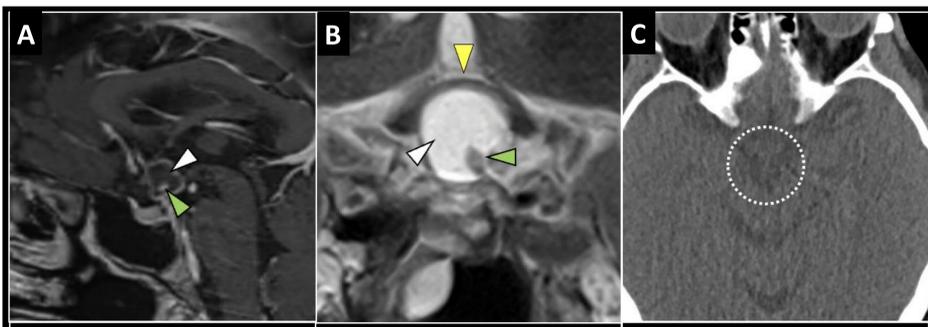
Preoperative Sagittal T1 C+ (A), Coronal T2 (B), Axial CT (C) demonstrating a solid-cystic mass (white and green arrowheads) extending to the base of the 3rd ventricle, suspicious for craniopharyngioma. The lesion caused compression and displacement of the optic chiasm (yellow arrowhead). Lack of calcifications on CT was suggestive of papillary craniopharyngioma
